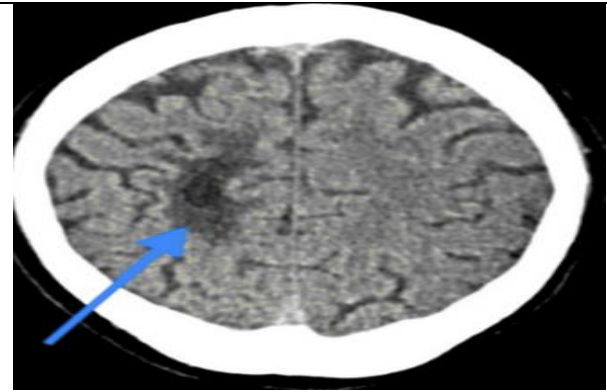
CT head without contrast: Blue arrows indicate encephalomalacia in the right frontal convexity region.
